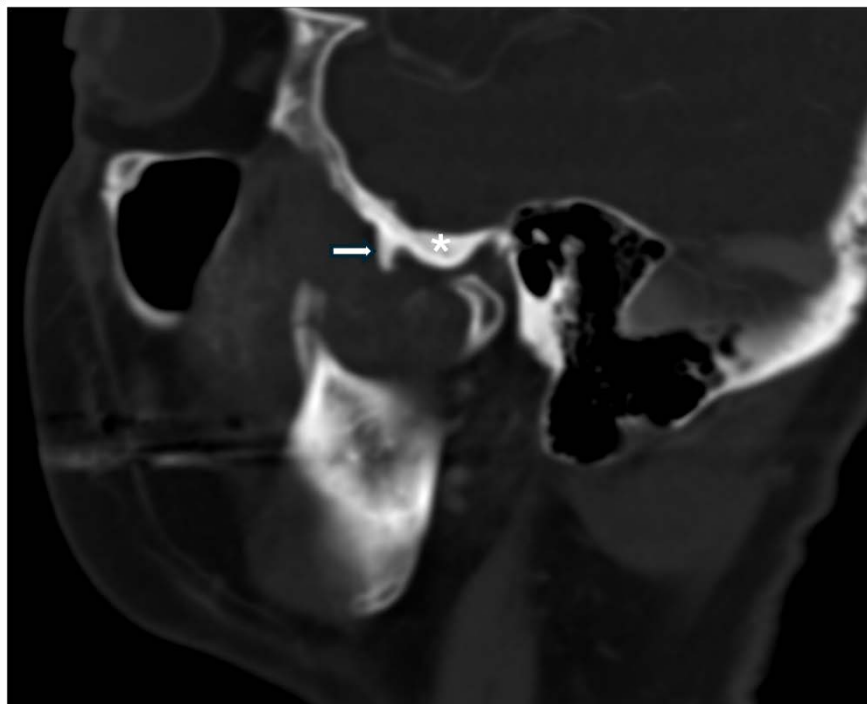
Contrast-enhanced CT (venous phase, bone window) shows a connection between the mass and the right temporal bone via a small bony stalk (arrow) anterior to the articular tubercle of the right temporomandibular joint (*).
